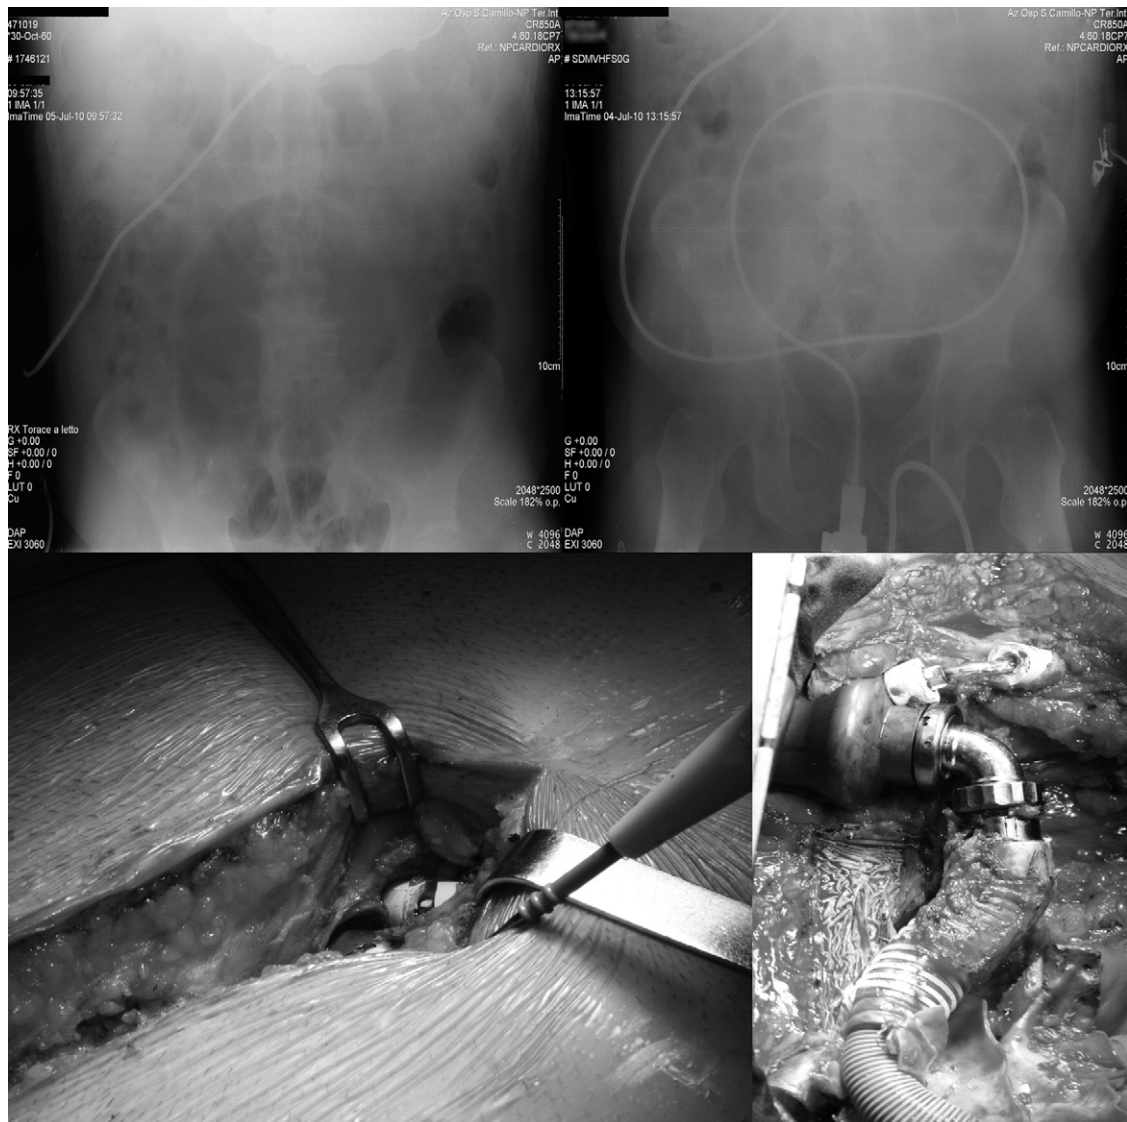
(Upper panels) X-ray imaging shows no apparent lesions in the length of the drive cable of the left ventricular assist device. (Lower panels) Intraoperative view shows the fracture of the proximal driveline tract that caused pump malfunction.
